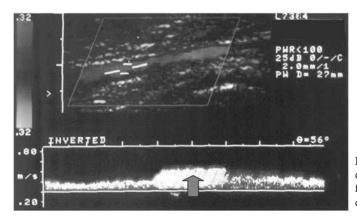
Duplex ultrasound image of the proximal third of the superficial femoral vein showing increase in venous flow velocity (arrow) on distal compression of calf compartment.
